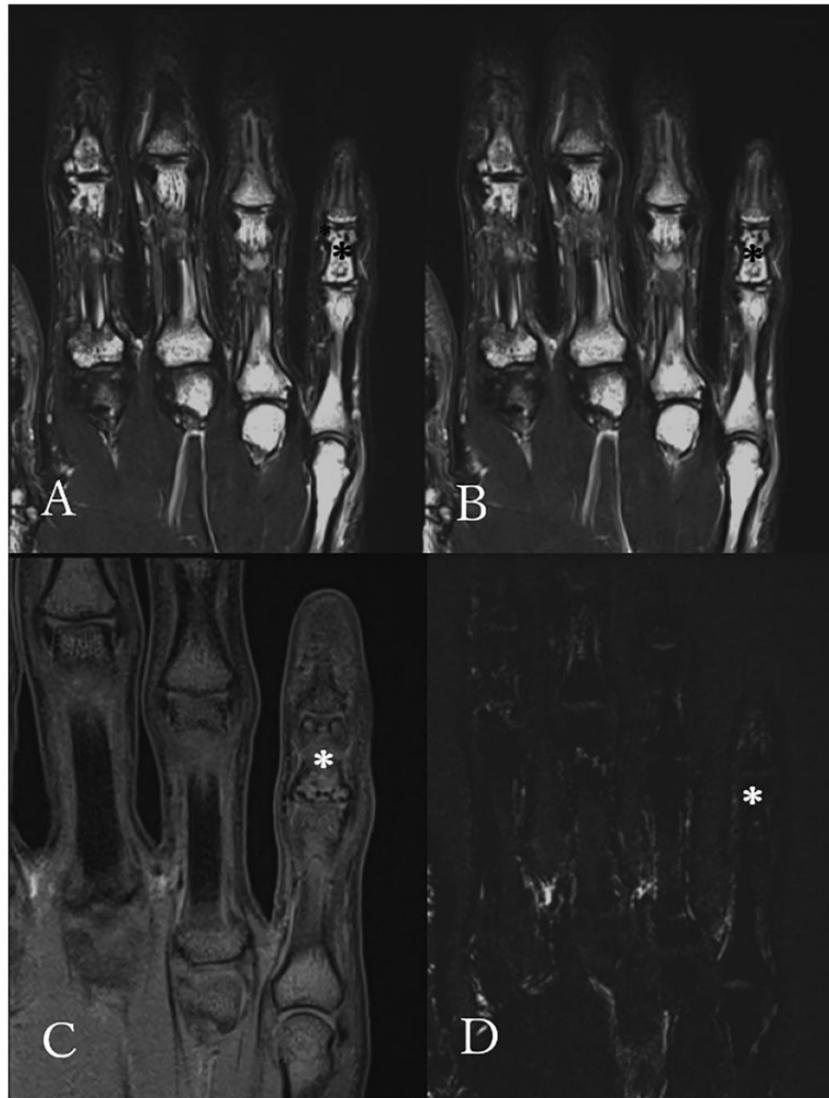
MRI of the right hand. (a) Coronal T2-weighted and (b) STIR image show very high signal in bone marrow and soft tissue, whereas (c) T1-weighted image shows iso-signal intensity to muscles. (d) DIXON fat image shows total lack of fat. *The osteolytic lesion detected on radiograph. MRI, magnetic resonance imaging.
